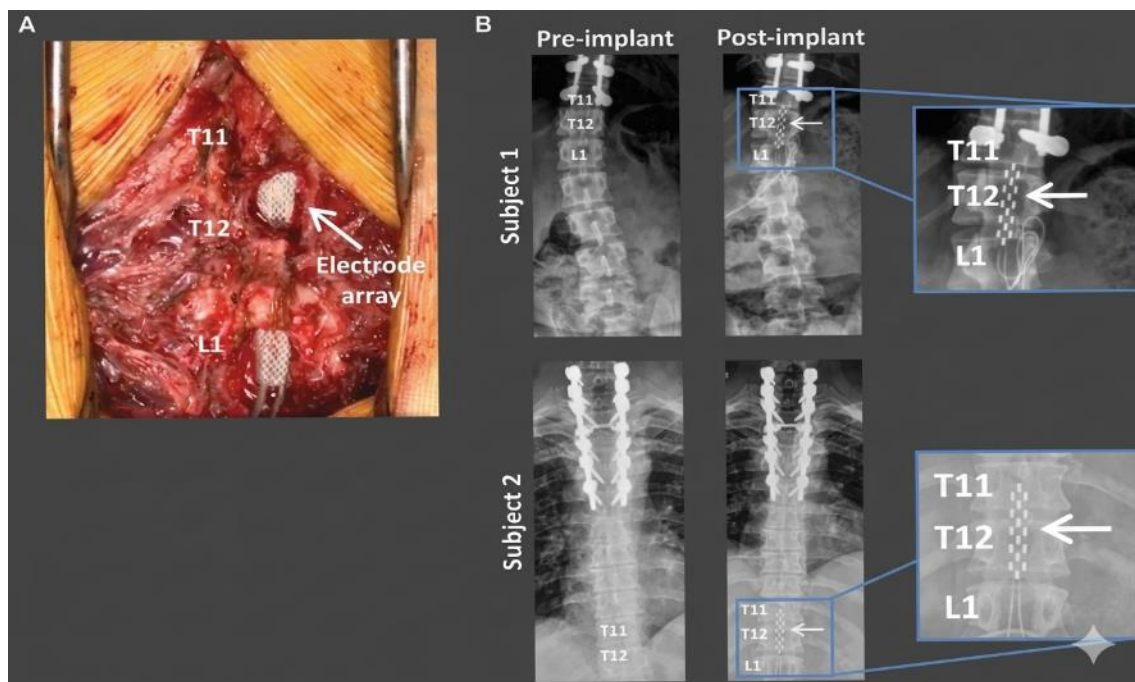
SCS surgical implantation. A) Intraoperative image of the electrodes array at T11-L1 levels. B) Anterior-posterior X-ray of two individuals before and after SCS implantation.
